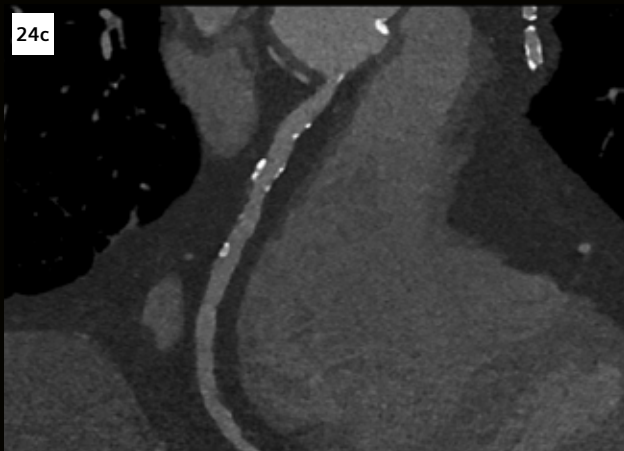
Coronary CTA using Quantum HD Cardiac in patient with calcium score of 1758. Curved MPR 0.2 mm (Fig 24a–c) | Cinematic VRT (Fig. 24d) | Bv56 | 120 kV | CTDI_{vol} 19.6 mGy. Courtesy of Semmelweis University, Budapest, Hungary
